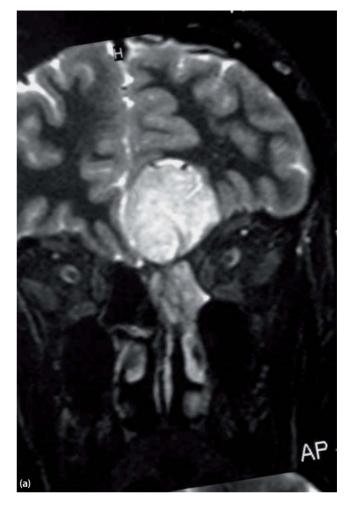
(a) MR and (b) CT scan of a patient with a Kadish C olfactory neuroblastoma. The tumour is characteristically centred on the cribriform plate.
